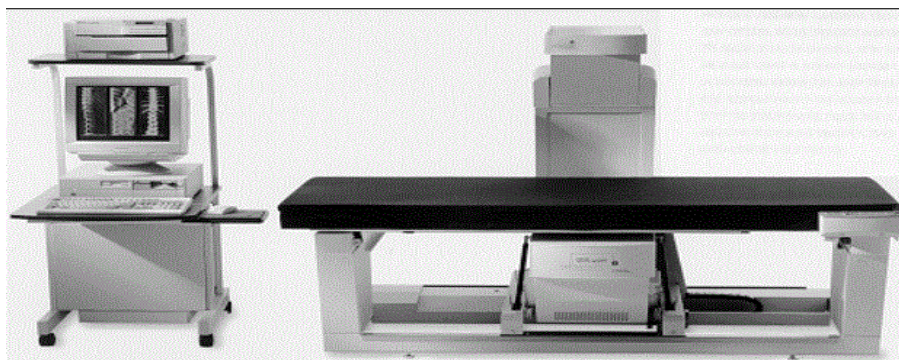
Dual energy X-ray beams (DEXA)
